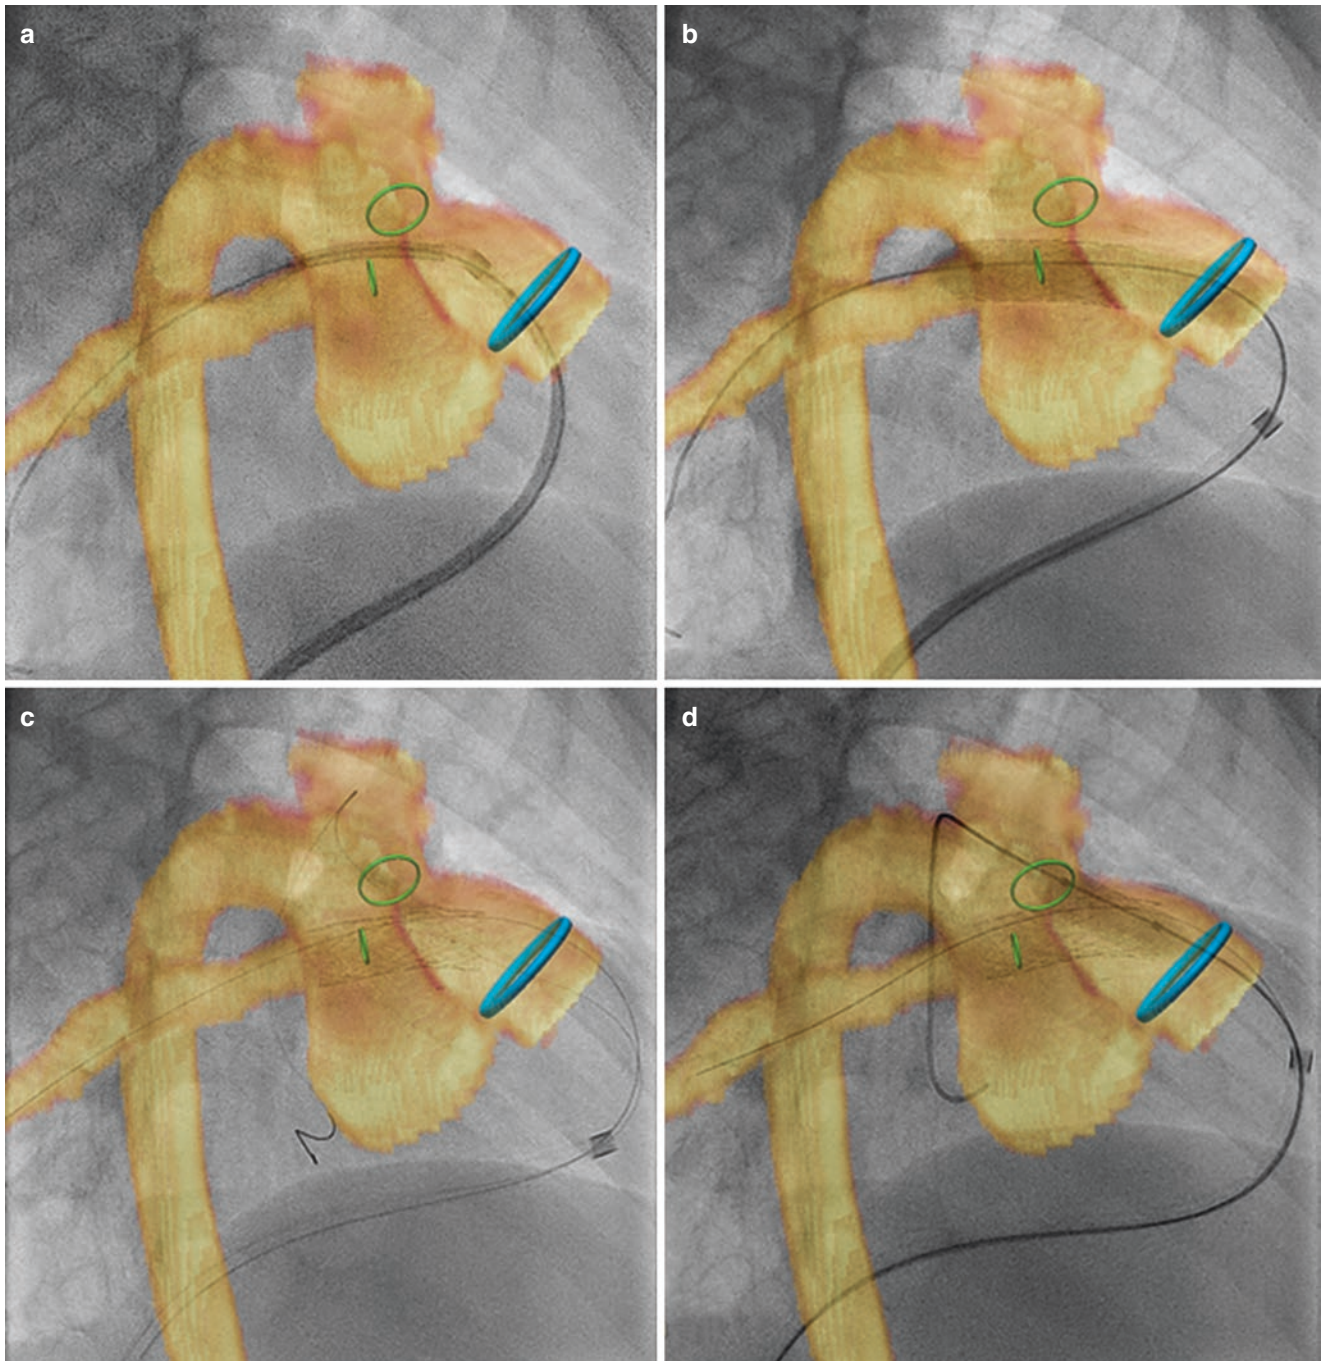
3D overlay with pictures generated from MRI with segmented vessels (PA and Ao = yellow) during treatment of pulmonary branch stenosis. Green rings are marking the stenotic part in RPA and LPA ostium. (a, b) Stent implantation of a Mega LD (Ev3, 26 mm) on
